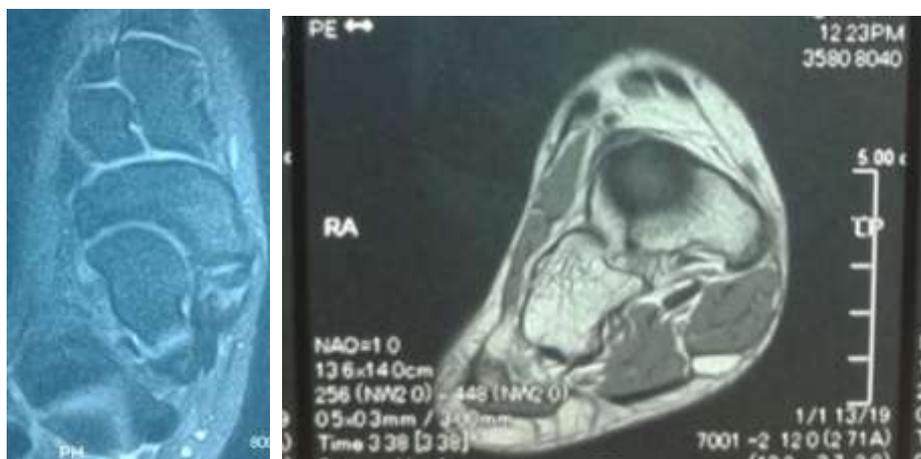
A magnetic resonance imaging demonstrating talo-navicular osteoarthritis with flattening of the navicular bone in the form of a distorted comma
